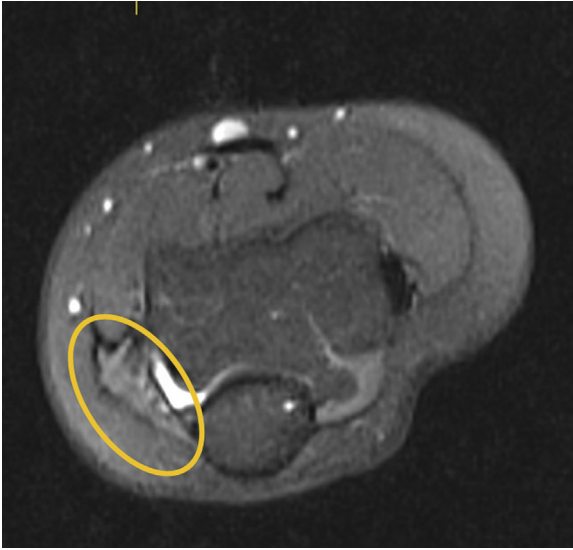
Magnetic resonance image showing the AE muscle inside the yellow circle.
